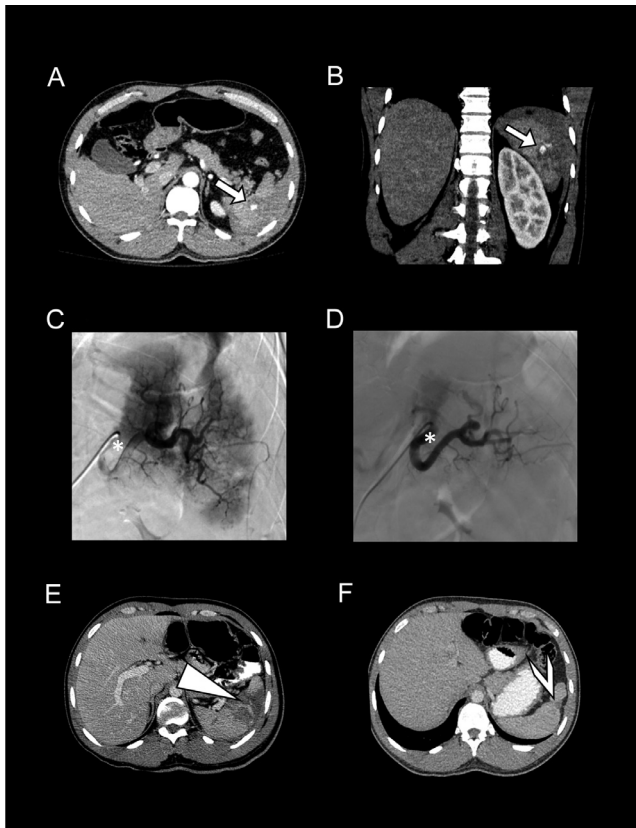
Imaging examples of splenic hemorrhage and angiography. This figure provides examples of computed tomography angiography and transarterial angiography findings in patients undergoing prophylactic splenic artery embolization. This is not intended to be a comprehensive overview of all patient imaging, but rather to provide visual context. (A and B) Computed tomography angiography evidence of an American Association for the Surgery of Trauma grade 3 splenic hemorrhage in patient A—specifically, there is perisplenic blood arising from a ruptured hematoma and contrast visualization, indicative of arterial extravasation versus pseudoaneurysm (white arrows). (C and D) Fluoroscopy segments of angiography performed in patient A, both pre- and post embolization, respectively. Of note, catheter placement and Gelfoam injection occurred at the proximal splenic artery (white asterisks), proximal to the dorsal pancreatic artery. The main splenic artery remained patent in all patients post embolization (D). (E and F) Axial sections of computed tomography scans obtained 2 and 68 days post intervention, respectively, in patient B. (E) A splenic laceration (white triangle) and resolving perisplenic fluid. (F) Resolving splenic laceration and a small area of scarring (white arrowhead).
